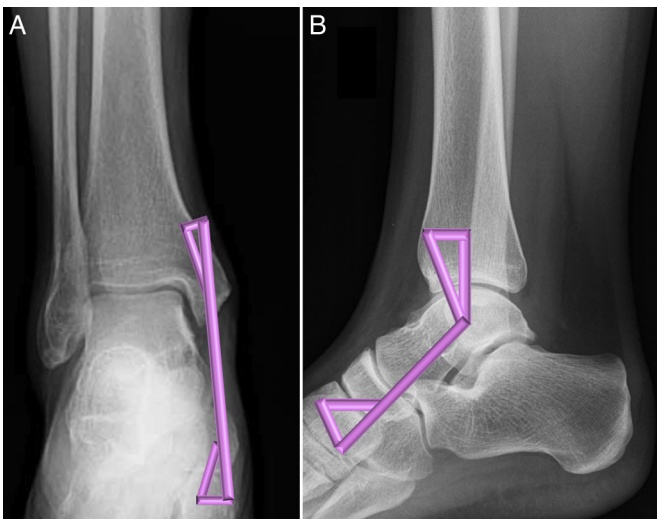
Deltoïd reconstruction (purple lines) as described by Raikin and Myerson (15) and Lack et al (16) using regional tissues demonstrated on (A) anteroposterior and (B) lateral radiographs. Metallic suture anchors are placed in the medial malleolus and medial talar body, and the sutures are placed in the deltoïd ligament and regional tissues in a fan-like fashion, approximating them to the medial malleolus.
